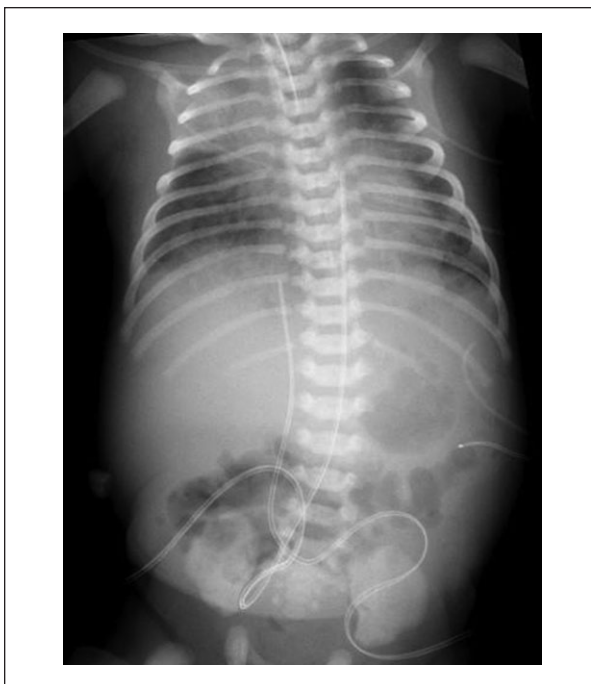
Day of life 1. Initial X-ray for line placement shows UVC tip at T9, UAC tip at T6, ET tip at T2.5, diffuse patchy lung infiltrate, and normal bowel gas pattern.
